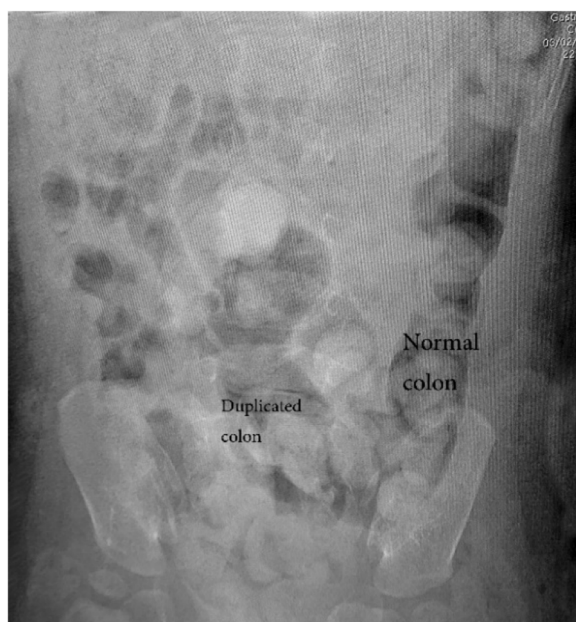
Plain abdominal X-ray before a double contrast study
